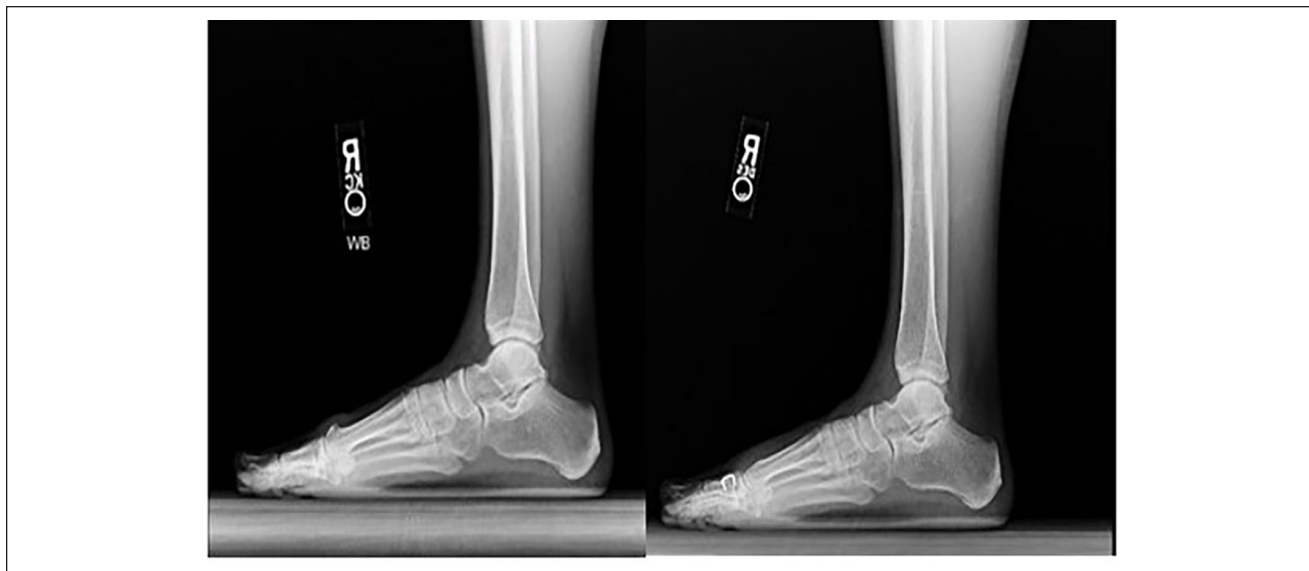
Preoperative (left) and OCM postoperative (right) lateral weightbearing radiograph. (OCM, open cheilectomy with Moberg osteotomy.)
